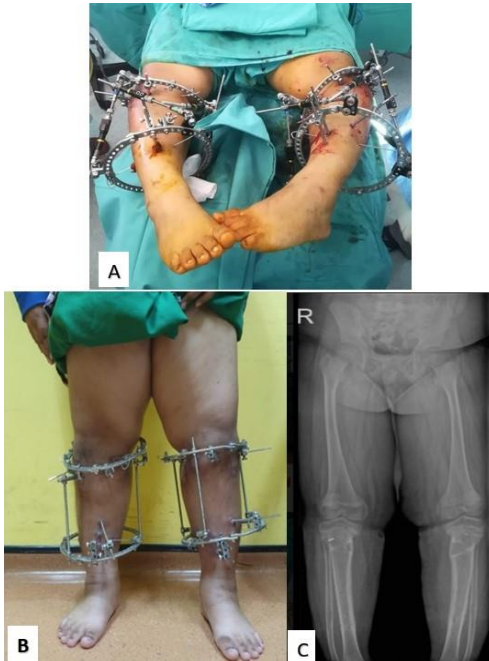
Fixation of the Ortho-SUV frame; b: Clinical photo of the child's legs just before removal of frame; c: long-leg radiograph showed the improved alignment of the lower limbs
